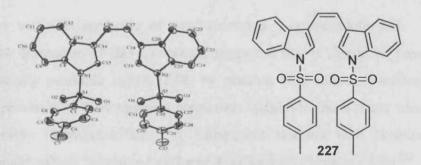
X-ray structure of compound 227
